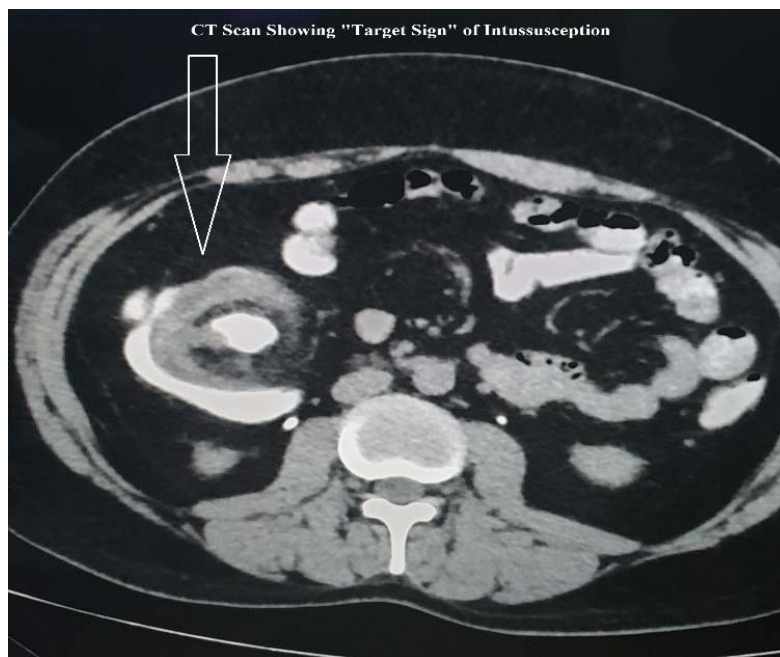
CT Scan of abdomen showing “Target Sign” of Intussusception
